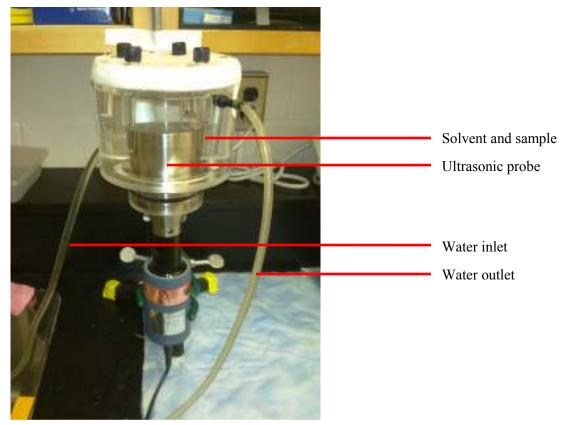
Novel indirect ultrasound-assisted lipid extraction apparatus.
